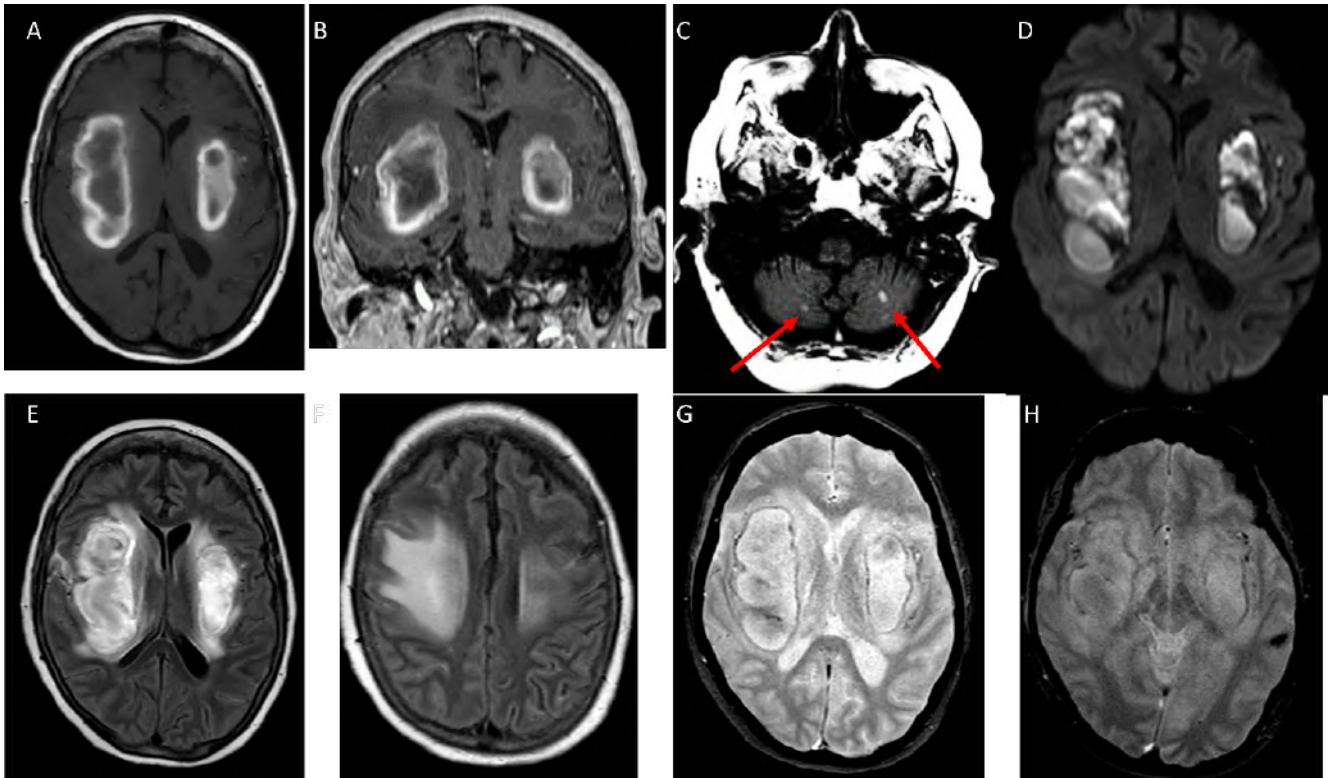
(A) Axial T1 spin echo (SE) showed central hypointense with peripheral hyperintense lesions on bilateral deep white matter with effacement of the lateral and third ventricles. (B) Coronal reconstruction of a volumetric T1 gradient-echo (GRE) showed central hypointense with peripheral hyperintense lesions on deep white matter. (C) Axial T1 SE showed two small hemorrhages on both cerebellar hemispheres (red arrows). (D) Diffusion-weighted imaging revealed possible restriction on bilateral deep white matter compatible with subacute hemorrhages. (E): Axial FLAIR at basal ganglia level showed hyperintensity lesions on bilateral deep white matter with surrounding edema. (F) Axial FLAIR at supraganglionic level showed extensive bilateral edema. (G): Axial T2* at basal ganglia level showed hyperintensity lesions on deep white matter with hypointensity due to subacute hemorrhages. (H) Axial T2* at lower basal ganglia level showed hyperintense lesions on bilateral deep white matter with hypointensity with blooming effect due to subacute hemorrhages and there was another small hemorrhage on the left temporal lobe.
